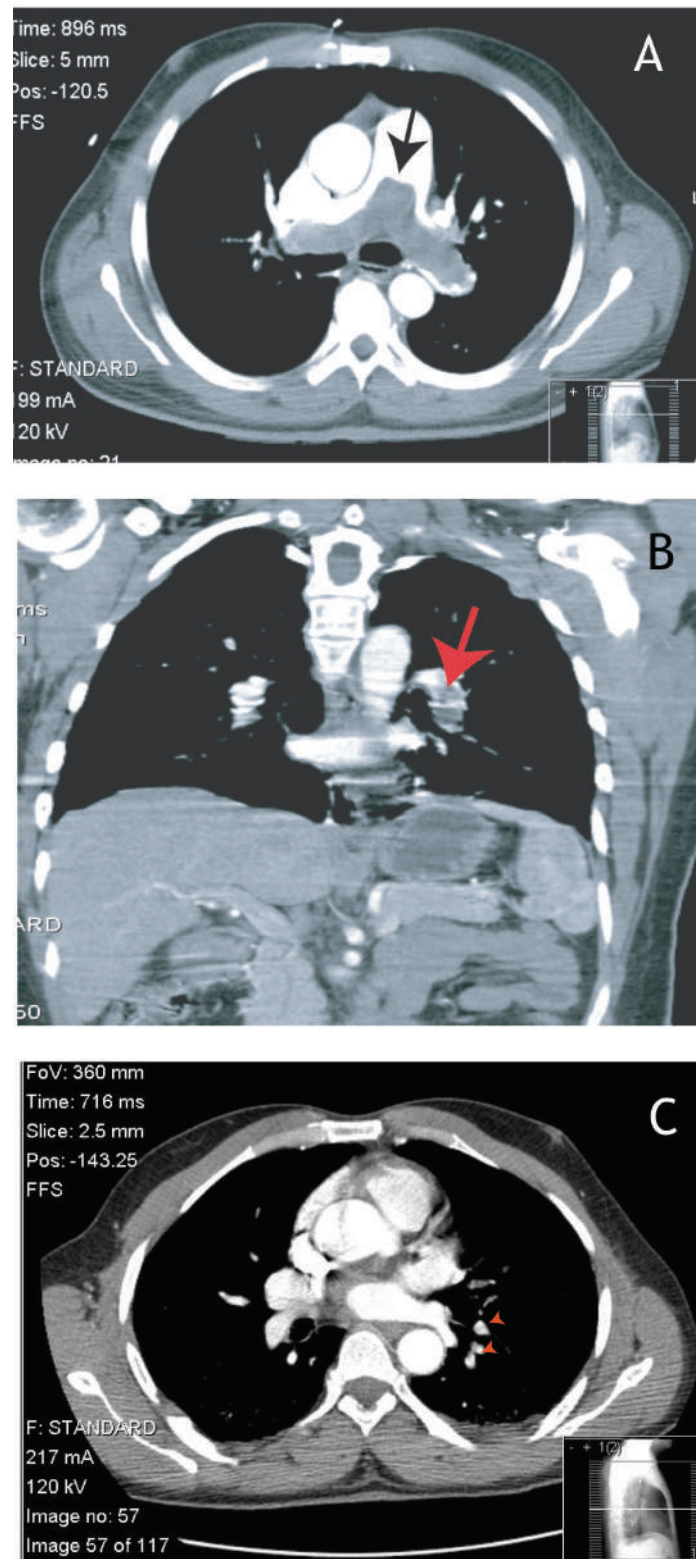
A. Computed tomography (CT) showing a saddle embolus (black arrow). B. CT showing a large left pulmonary artery embolus (filling defect, red arrow). C. CT showing a left pulmonary artery embolus (filling defect, red arrows).
